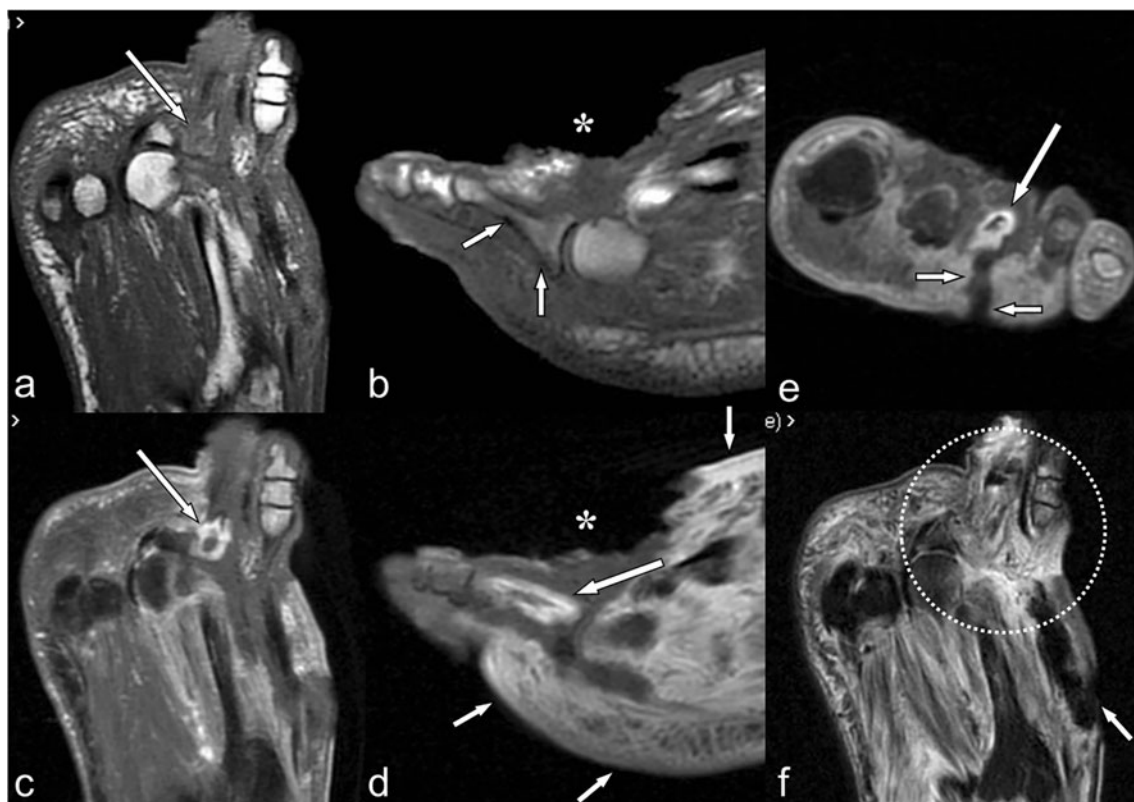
Abscess and osteomyelitis in a 73-year-old diabetic woman who had undergone aggressive sharp debridement of her ulcers 2 days earlier. a Axial and b sagittal T1-weighted MR images, obtained at the level of the forefoot, show an extensive region of hypointensity in the marrow of the third proximal phalanx suggesting osteomyelitis (*arrow* in a, *small arrows* in b). c Axial, d sagittal, and e coronal, post-contrast, T1-weighted, fat-suppressed MR images show a thick rim enhancement of an intraosseous fluid collection (*arrow* in c–e) extending to the deeper aspect of a plantar ulcer (*small arrows* in e). The plantar aspect of the ulcer does
